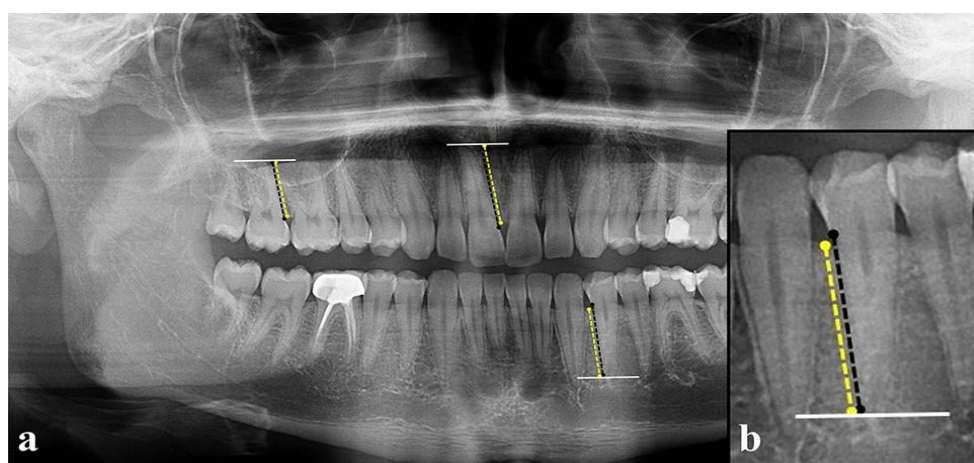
Dental radiography
